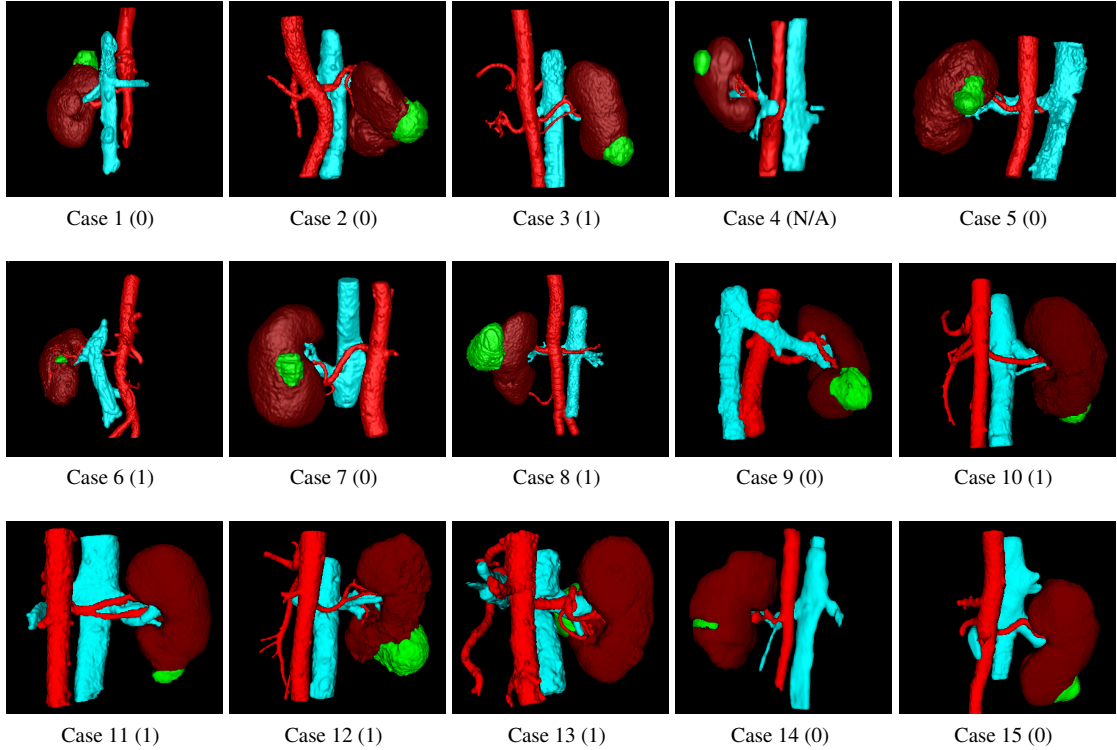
Manually segmented computed tomography (CT) scans of each surgical case with the number of accessory vessels included in parenthesis, showing kidney (brown), tumor/cyst (green), veins (cyan), and arteries (red).
